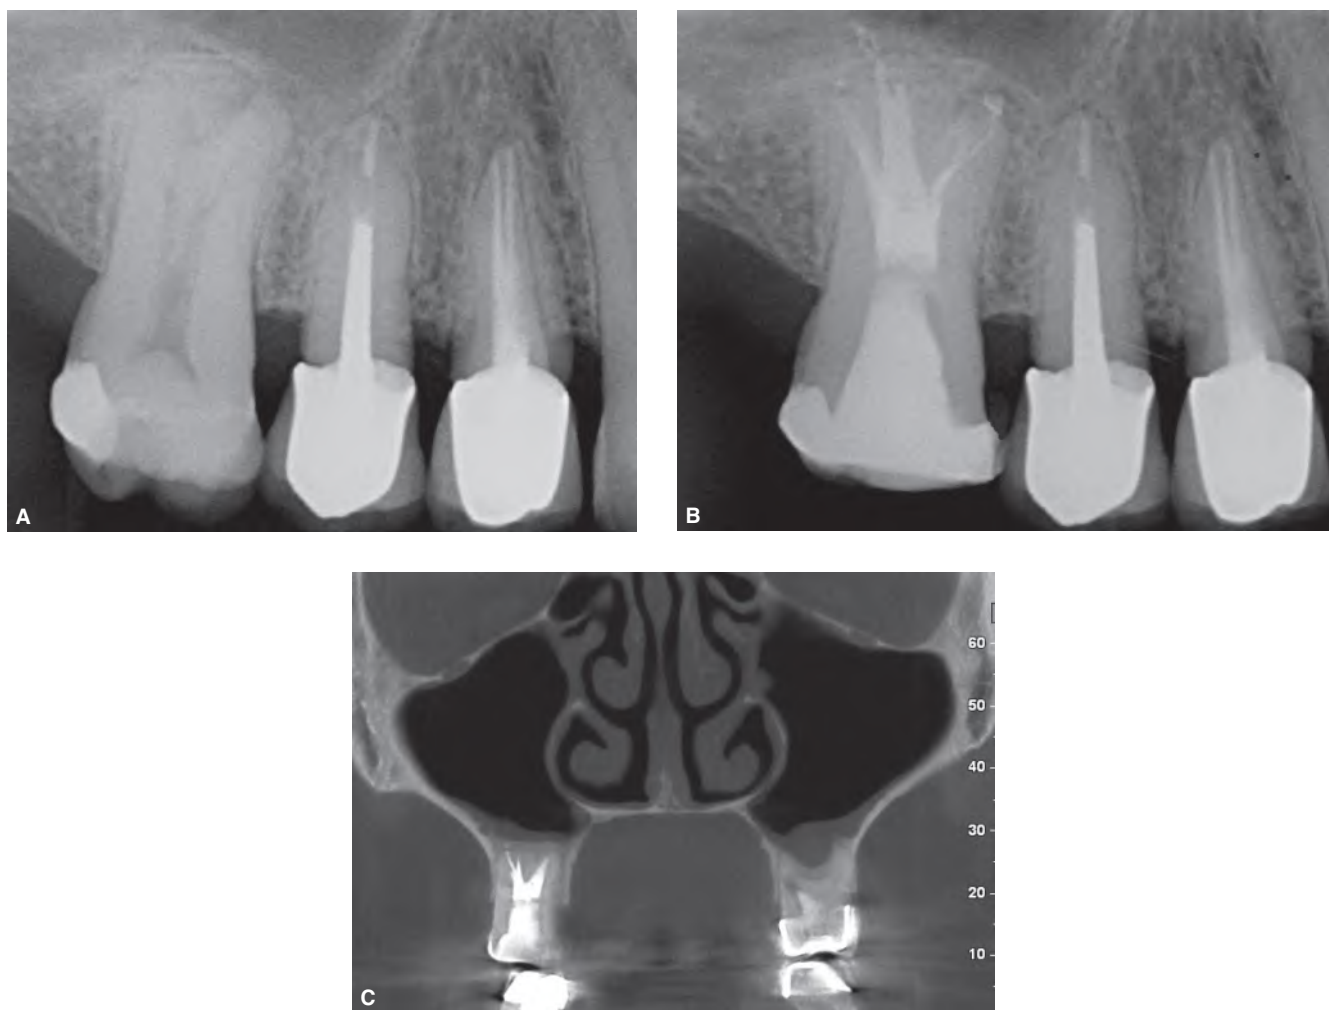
Taurodontisms (hyper-type) in a maxillary first molar of a 55-year-old male. Patient complained of pain and chronic sinusitis. A. Preoperative radiograph. B. Immediate postoperative radiograph following nonsurgical endodontic treatment. C. CBCT (Newtom) image showing the complex anatomy. (Courtesy of Dr. Jean-Yves Cochet, Paris, France.)
